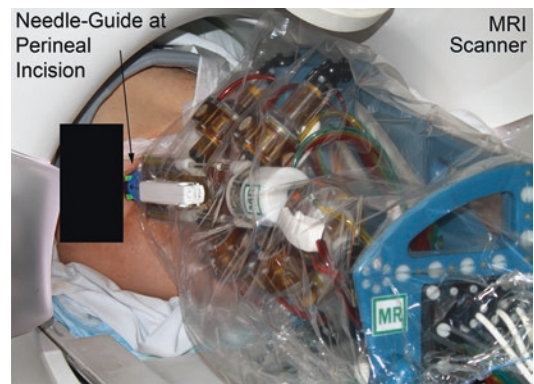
Displays a patient in left lateral decubitus position within the MRI scanner. The MrBot is mounted to the MRI table and placed at the perineum
